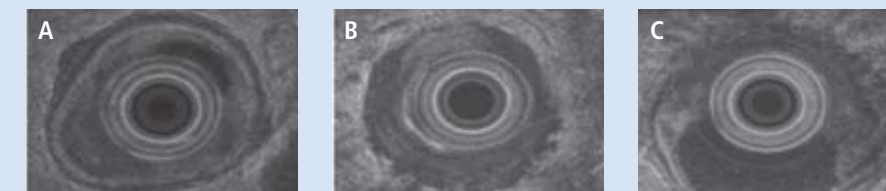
Transrectal ultrasound staging of rectal cancer determines the need for preoperative radiation therapy and chemotherapy. (A) Stage T1 cancer limited to the mucosa, not requiring radiation. (B and C) Stage T3 and T4, respectively, invading the muscularis propria (B) and the adjacent bladder (C), both necessitating radiation.
